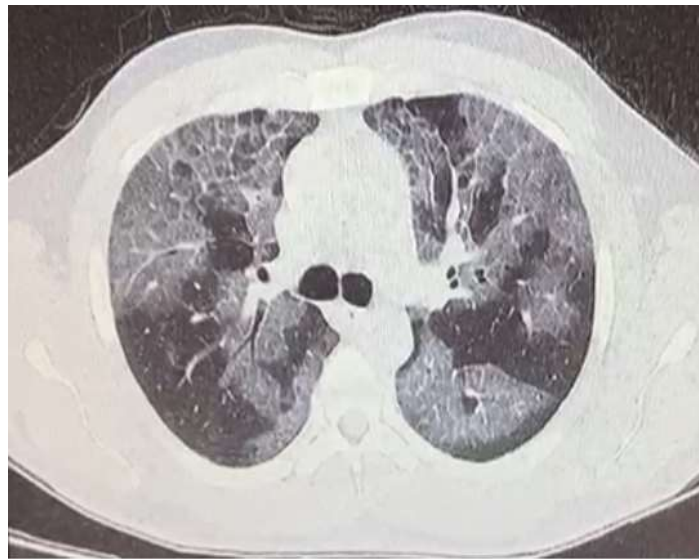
High resolution computed tomography of patient showing crazy-paving pattern
